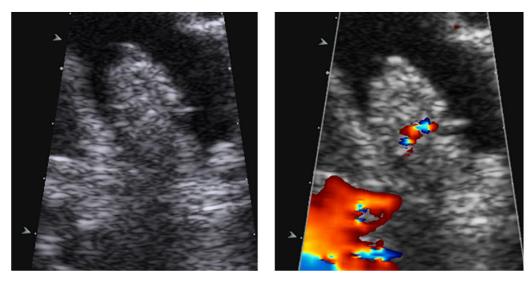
a, b Gallbladder adenoma, colour coded sonography with proof of perfusion (b); FS right with CCDS
